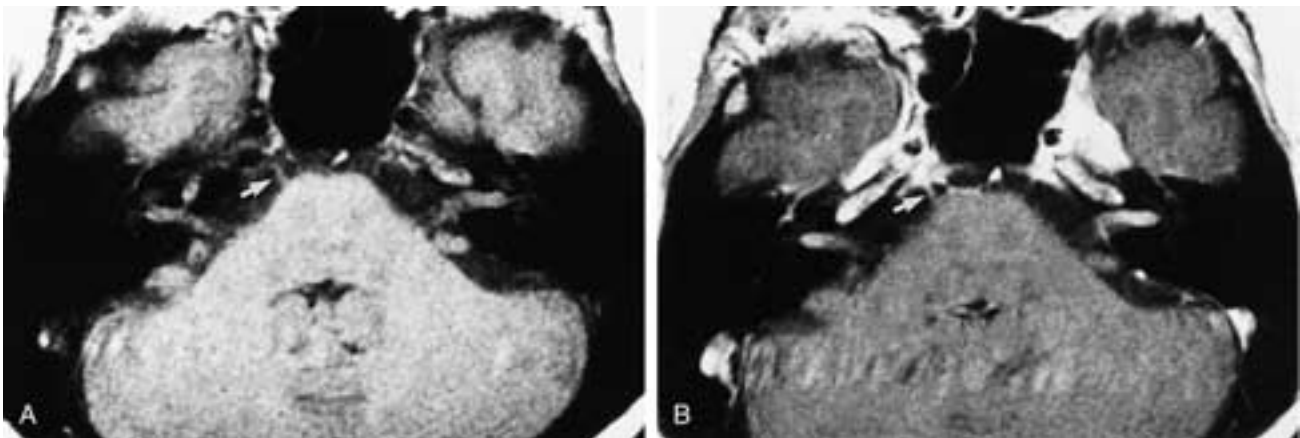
Bilateral IAC lymphoma. A, T1-weighted image shows IAC tumors isointense to the pons. B, Gadolinium T1-weighted image shows moderate to marked enhancement of the tumors. The patient also had similar involvement of the trigeminal nerves (not shown) and the abducens nerves (*arrows*), partly shown on this section.
